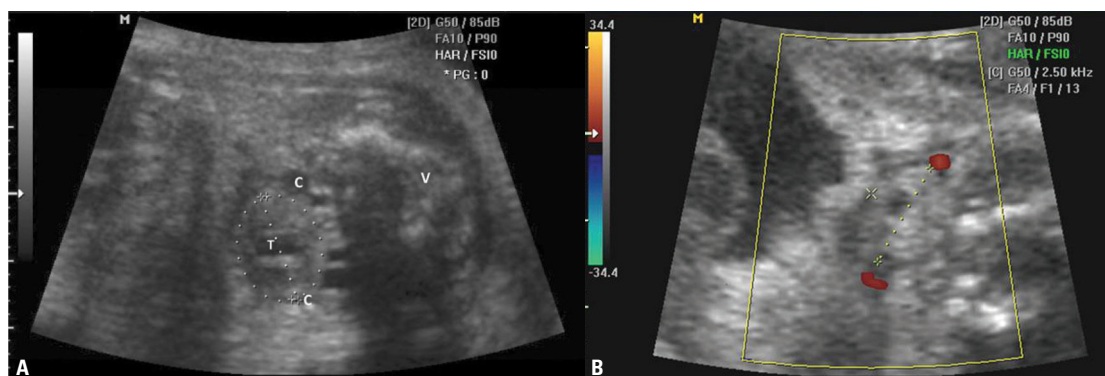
Normal foetal thyroid at 31-wk gestation on US transverse scan. Thyroid gland is placed inside the calipers, with the carotid arteries outside, trachea in the middle, and cervical vertebra located posterior (A). Blood flow visible only within carotid arteries, absent in thyroid gland on colour Doppler examination (B). The examination was performed with Accuvix XQ Medison scanner and abdominal convex transducer 3–7 MHz
